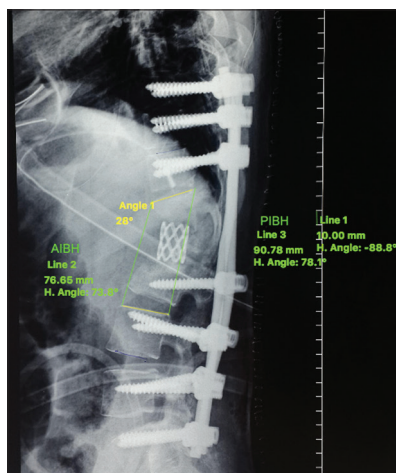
Two X-ray of tuberculosis of the spine showing D11, D12, and L1 complete destruction with partial destruction of D10 and L2 vertebral superior end plates of immediate contiguous vertebrae, that is, D10 and L3 were considered for calculation of radiological parameters, and the same landmarks were used for calculation in follow-up
